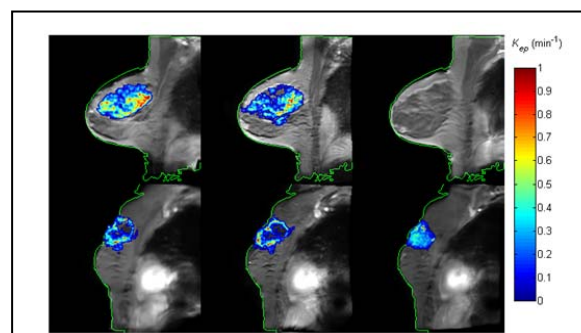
The k_{ep} parametric map superimposed on the post-contrast DCE-MRI data at three time points for one pCR (top row) and one non-pCR (bottom row). For each patient, the maps obtained at each time point were registered to the same image space.
